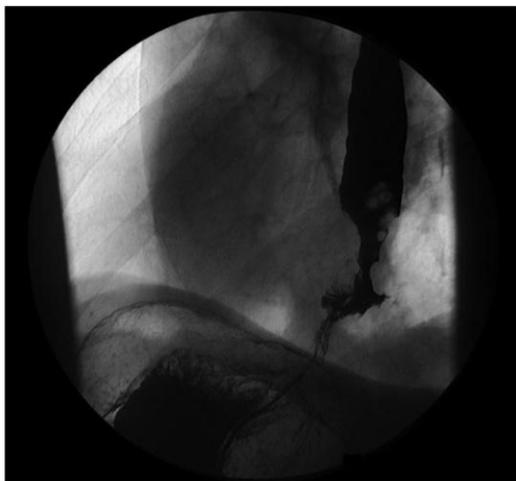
Barium swallow radiograph in a patient with adenocarcinoma of the distal esophagus. Note narrowing of the esophageal lumen with irregular mucosal contour. When similar lesions are in mid or proximal esophagus, they usually are squamous cell cancers. Endoscopic biopsies are required to establish the diagnosis.
